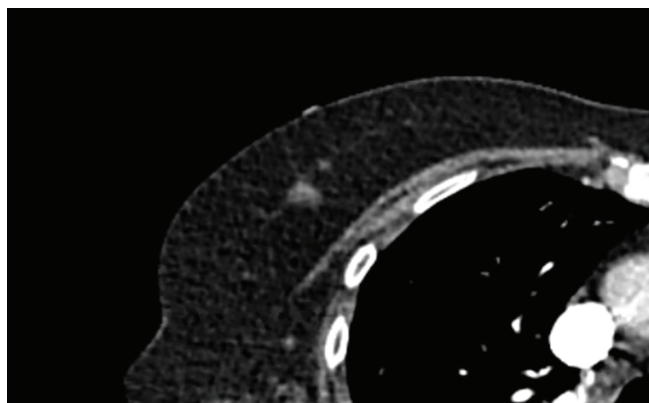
An incidental right breast mass of 12 mm on chest CT scan
